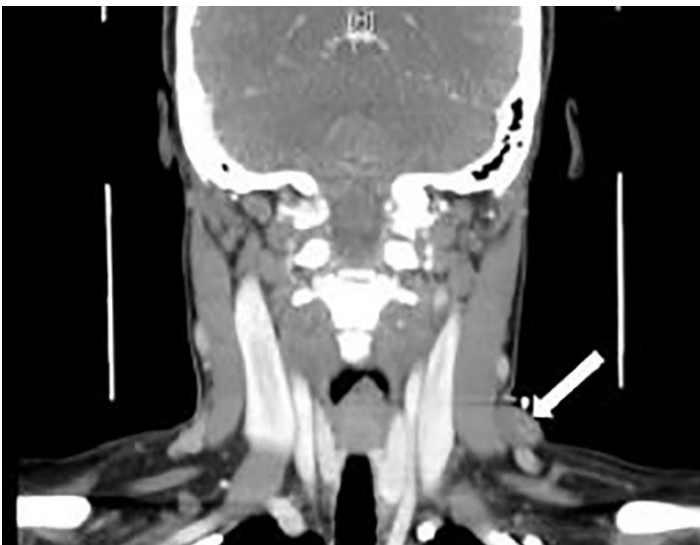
Computed tomography with contrast coronal view of left external jugular venous pseudoaneurysm (arrow).
